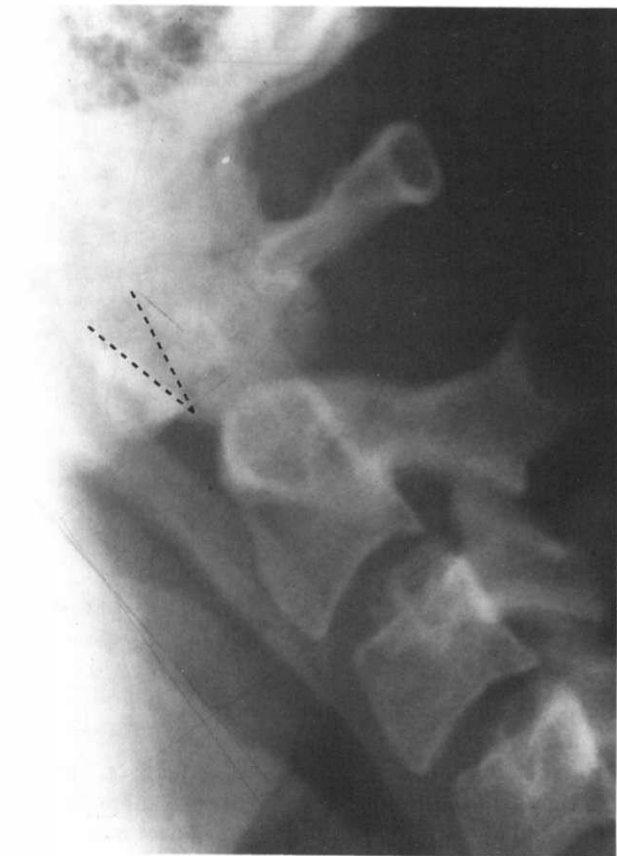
Roentgenogram of a 20-year-old male following an automobile accident in which he was the driver in a head-on collision. He hit his head on objects inside his auto, which forced his neck into extension. There were no neurologic symptoms, and the neurologic and orthopedic examinations were normal. He had persistent neck pain that subsided, and he gradually returned to normal activities. This "V sign," with tilting of C1 in relation to the dens, is thought by some writers to indicate instability. However, other writers disagree. We suggest that it may be due to congenital absence or laxity of the ligaments. See Figure 5-12 for the anatomy. We do not believe that this condition represents clinical instability.
